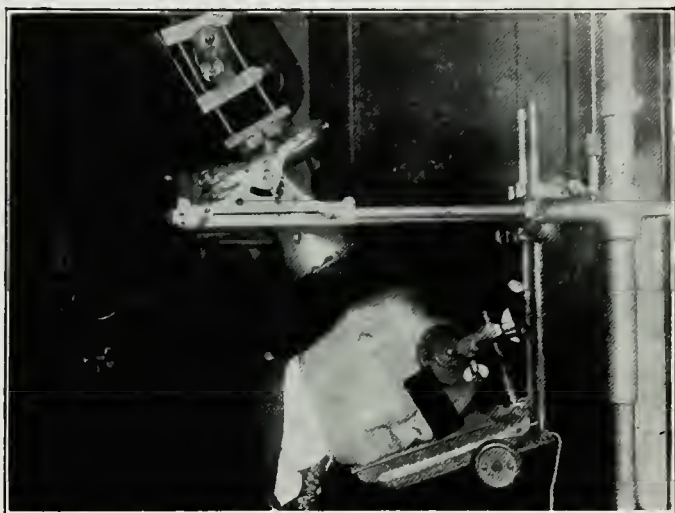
Position of head and angle for left side of maxillae when Eisen plate rest is used with stand for taking roentgenograms of jaws.
